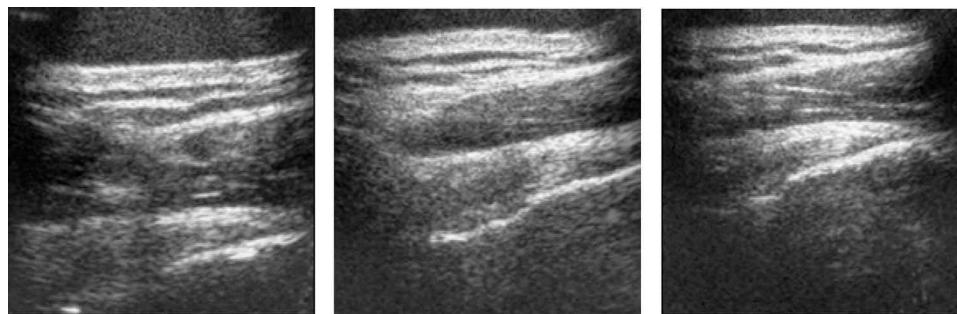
Ultrasound image acquired with three force levels.
